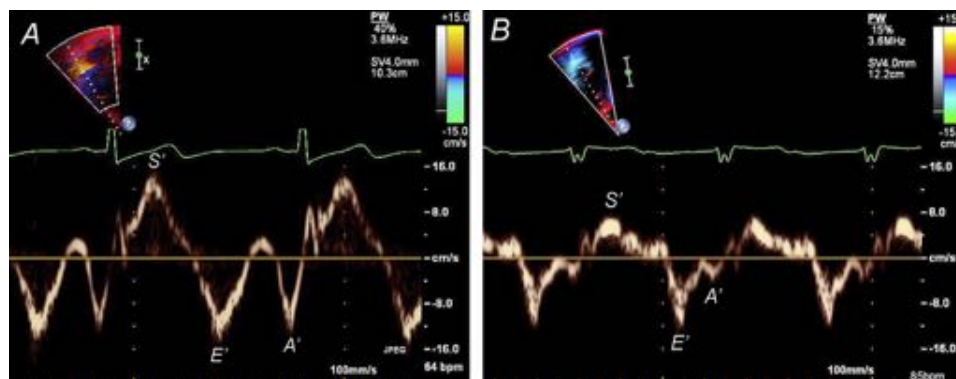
Tissue Doppler of (A) normal (peak S' velocity, 14 cm/sec) and (B) depressed (peak S' velocity, 7 cm/sec) RV systolic function.
